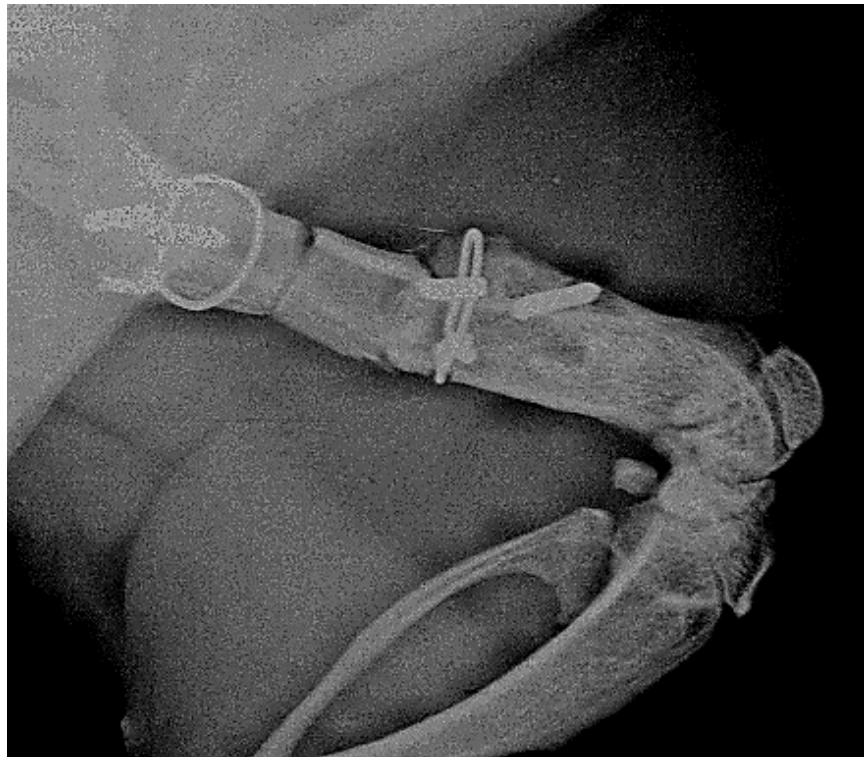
Healing of the control (allograft without growth factor) after 4 weeks. No visible healing is evident on the radiograph.
